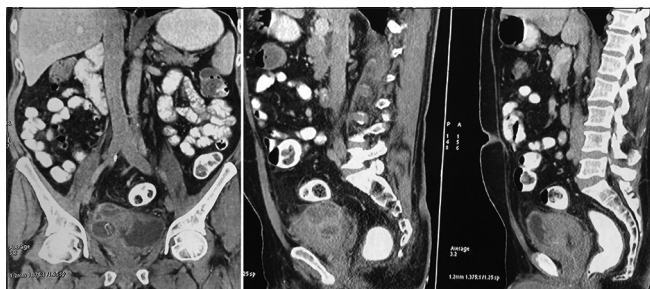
Coronal and sagittal plain CT scan images showing multiple cystic lesions with round to oval pockets of fluid collection attached to the right lateral wall of the urinary bladder.
